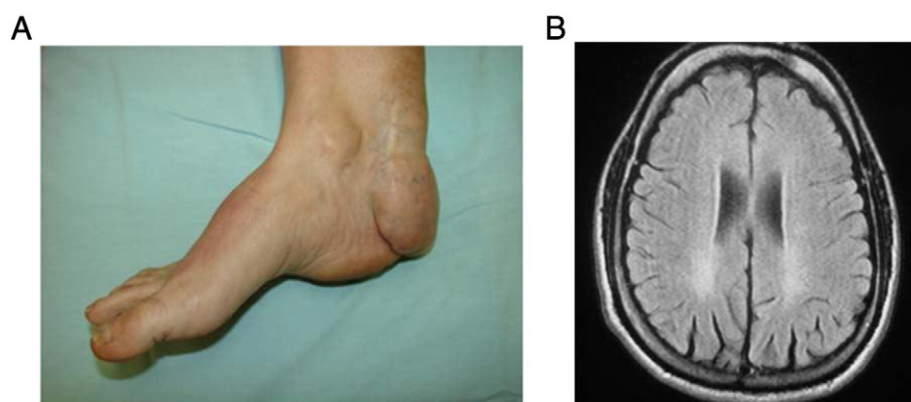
The plasma sample analyzed was from the daughter of a non-consanguineous couple, with two possibly affected siblings that died at 24 and 55 years old with neurological symptoms suggestive of CTX. The daughter had developed cataracts at age 22 years old that were surgically corrected and Achilles tendon xanthomas from age 13 (left panel) that could not be alleviated with surgery, resulting difficulty in walking and intense pain in the feet and knees. There was spastic gait present (pyramidal tract syndrome) with no ataxic manifestations, extrapyramidal signs or dementia, although an MRI of the brain showed bilateral occipital periventricular white matter signal hyperintensity on T2 and Flair (right panel).
